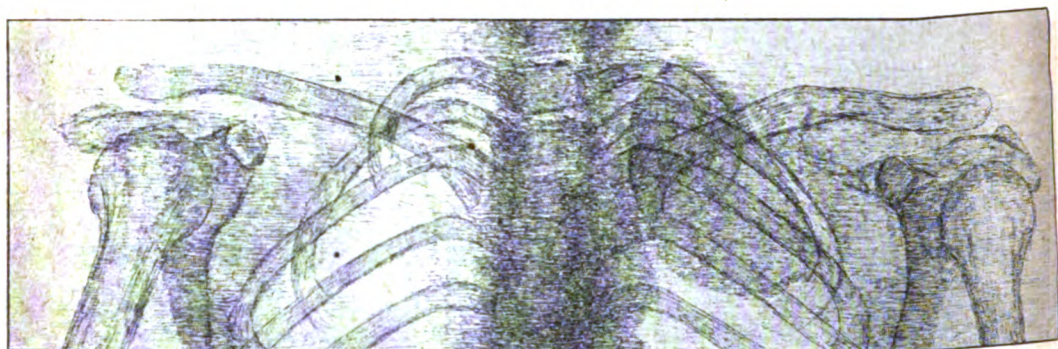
Sketch by Captain Crowe, R.A.M.C., of the upper part of the chest from X-ray plates and screen examination. The position of the aneurysm is seen.
